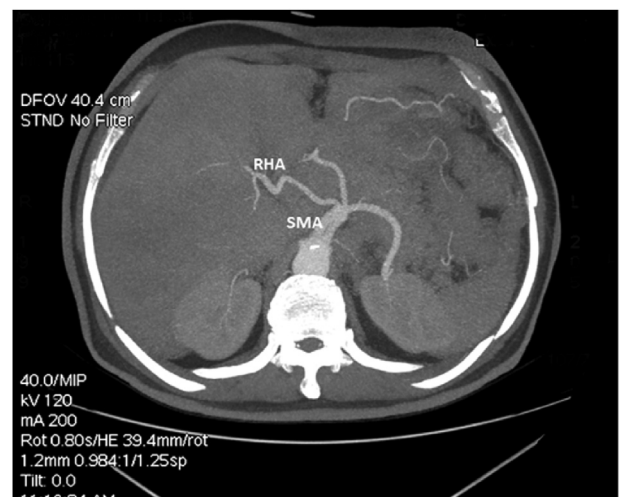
Enhanced arterial phase CT image showing RHA arising from SMA (Michel's type III).
